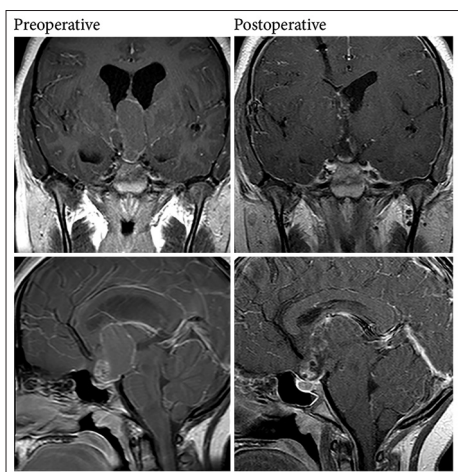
Preoperative (left) and postoperative (right) T1-weighted magnetic resonance imaging with contrast images from the patient in Case 1. Coronal (top) and sagittal (bottom) images
